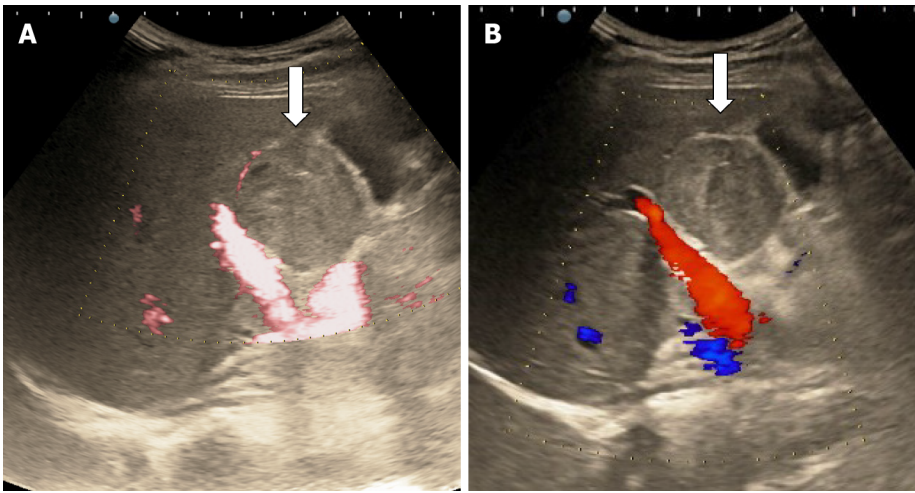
Doppler mode ultrasound for hepatic hemangioma. A and B: No intralésional vessels are seen at power (A) or color Doppler (B) exam due very slow intralesional flows.
